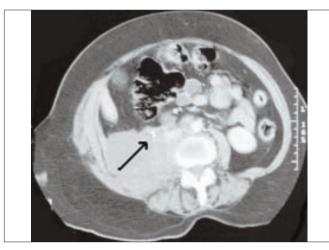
CT section showing psuedomyxoma extraperitonei (arrow pointing towards ureteric stent).
